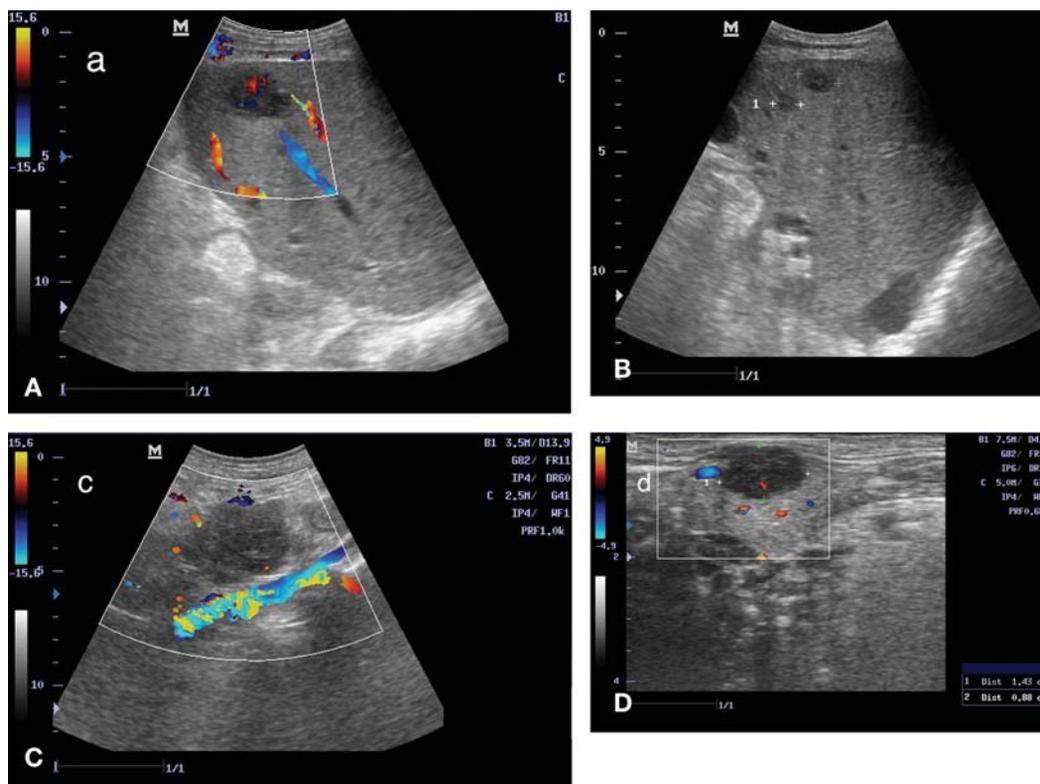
Imaging studies: A. Abdominal ultrasonography revealed irregular hypoechoic nodule in the right lobe of the liver, 27.5x23 mm diameter, with positive color Doppler signal. B. Multiple irregular hypoechoic nodules throughout the liver. C. A retroperitoneal mass of 86 x 53 x 39 mm, with hypoechoic inhomogeneous structure, ill-defined margins, arising from pancreas, adjacent to the inferior vena cava. D. Right parotid ultrasound revealed a well-delineated hypoechoic nodule, 16/9.2 mm, with visible color Doppler flow.
